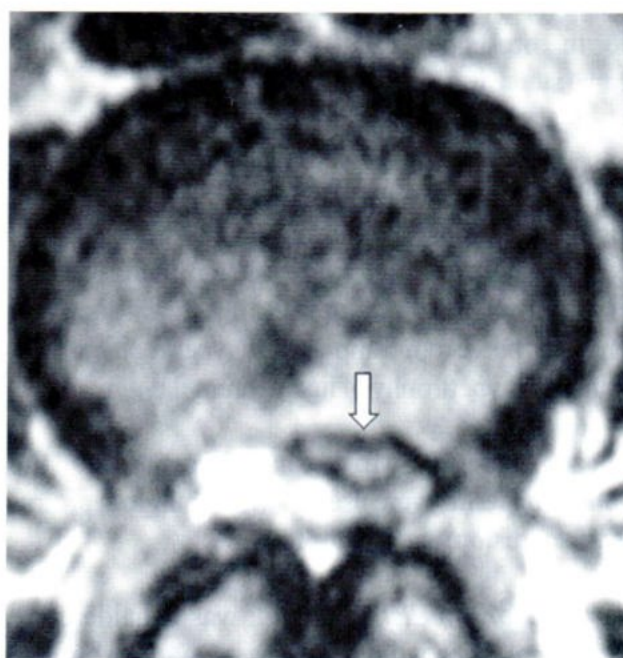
Disk sequestration. Axial T2-weighted SE MR image of the lumbar spine in a 40 year-old man with low back pain, severe radicular pain and positive straight leg raising test showed a free disk fragment (white arrow).
